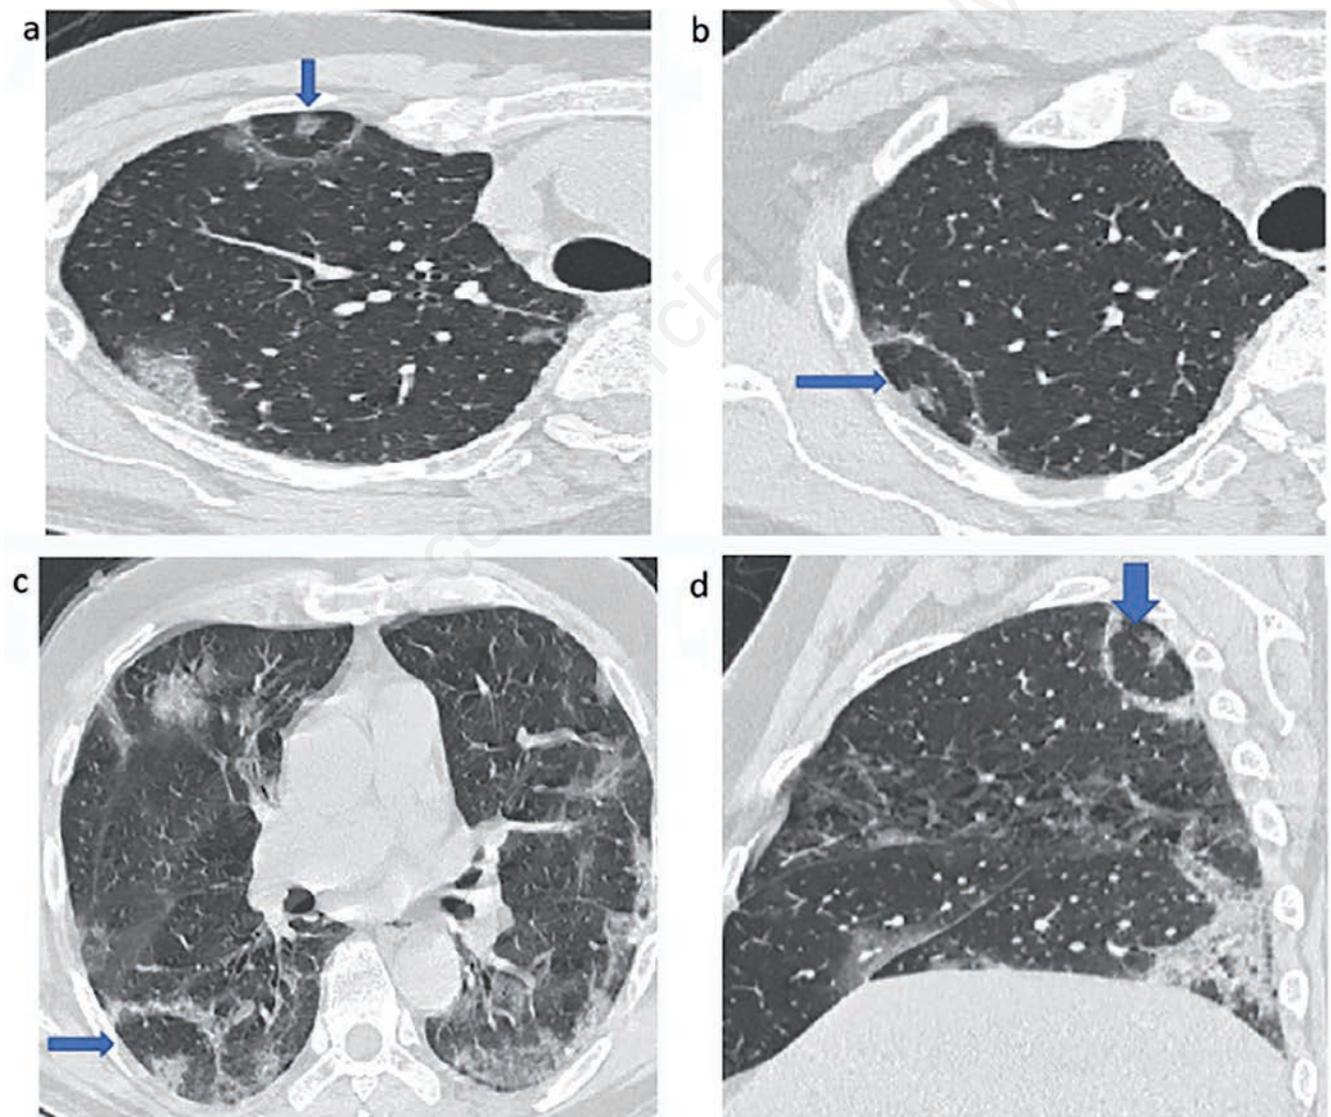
HRCT (on day 10 of illness) showing Bull's eye sign in a 67-year-old male complaining of fever, cough and fatigue. Axial (a-c) and sagittal (d) CT image showing centrilobular nodule surrounded by an inner ring of air (the spared pulmonary lobule) surrounded by an outer ring of consolidation which is perilobular in location. Areas of consolidation are seen in peripheral subpleural location in both the lower lobes.
